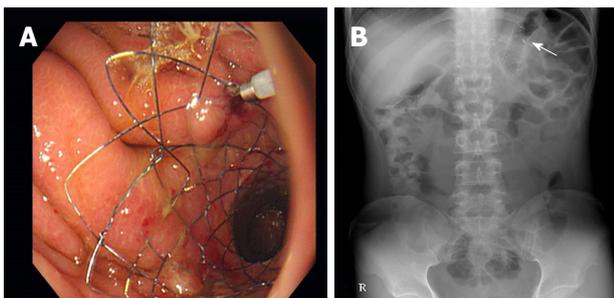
Inset self-expandable metal stent. A: A stent is deployed at the anastomotic site with endoscopic clips; B: The stent is identified on an abdominal radiograph (arrow).
